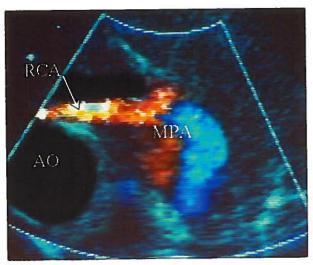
Parasternal short axis scan at the level of aortic and pulmonary valves. Color Doppler shows retrograde flow from the right coronary artery into the main pulmonary artery. AO= aorta; MPA= main pulmonary artery; RCA= right coronary artery.
